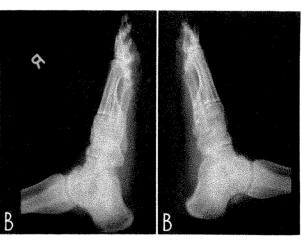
September 27, 1935. A, dorsoplantar roentgenogram showing beginning medial displacement of right astragalus and area of rarefaction of left. B, lateral view showing destructive changes in each astragalus and irregularity of right navicular.
